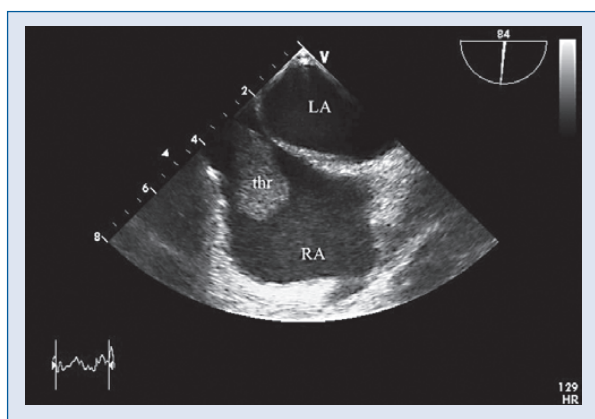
Transesophageal echocardiography, basal short-axis view at mid-esophageal level (angle 84°) showing the thrombus free in the right atrial cavity; LA — left atrium; RA — right atrium; thr — thrombus.
